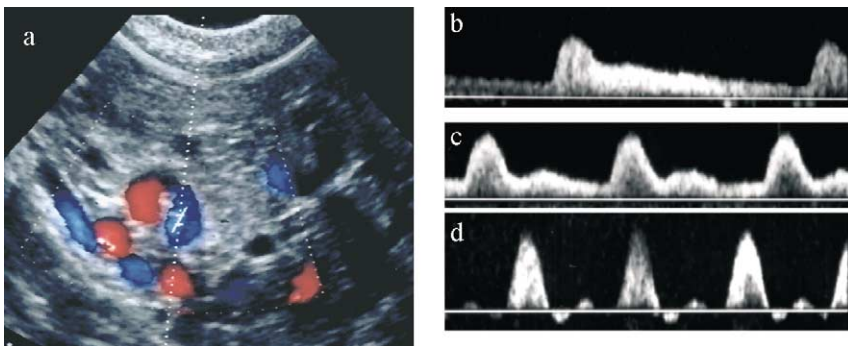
Convoluted aspect of testicular artery: (a) Color Doppler ultrasound image; (b) monophasic non-resistive waveform; (c) biphasic, resistive waveform; and (d) biphasic, highly resistive waveform with retrograde flow.
